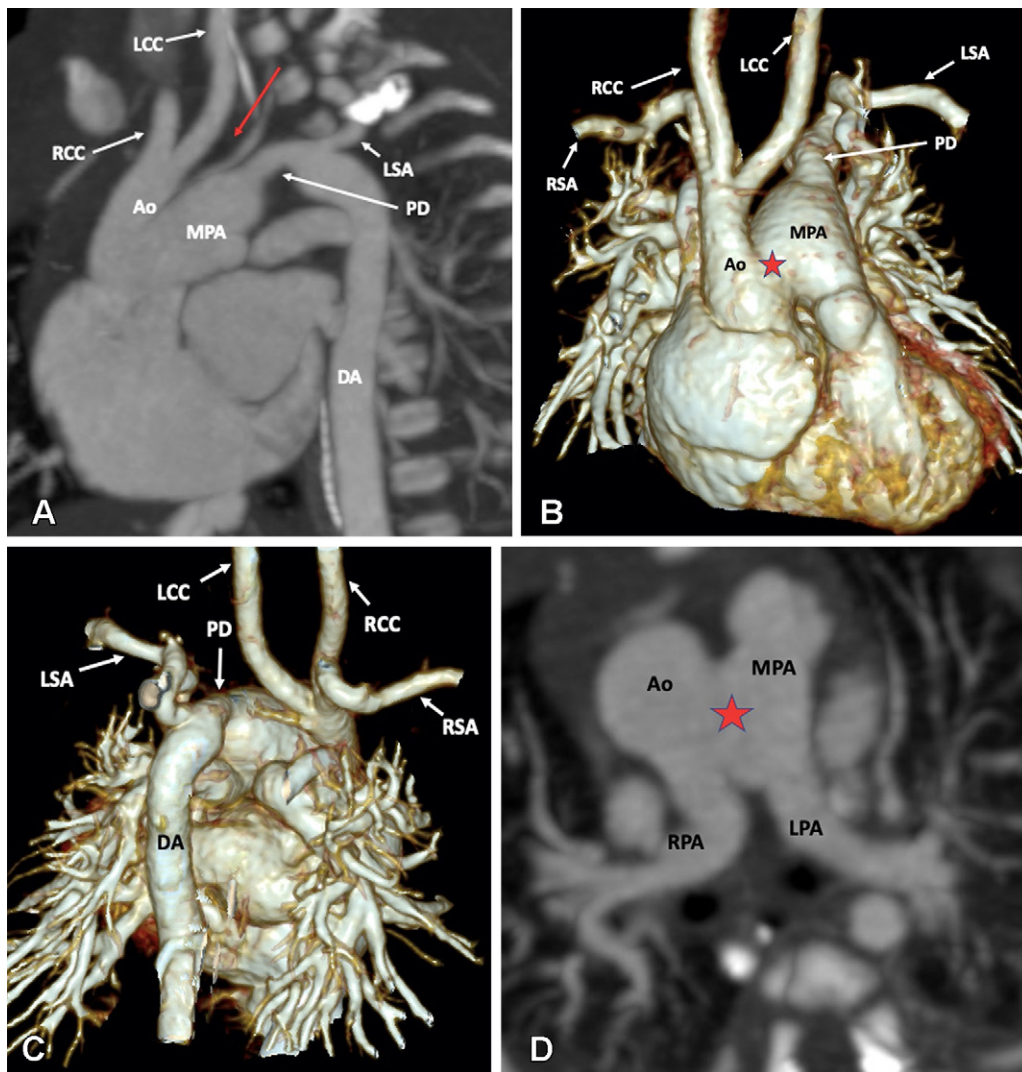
Preoperative appearance of type B interrupted aortic arch with aortopulmonary window in a neonate. (A) Sagittal oblique maximum intensity projection (MIP) CT image shows interrupted aortic arch (red arrow). Both the right and left common carotid arteries arise from the arch proximal to the site of interruption. The descending thoracic aorta is filled by a large left patent duct connecting the left pulmonary artery and descending thoracic aorta. (B) Anterior and (C) posterior three-dimensional volume-rendered images confirm the aortic arch interruption. The proximal ascending aorta and pulmonary trunk are connected, suggesting aortopulmonary window (red star in B). (D) Axial MIP CT image shows aortopulmonary window (red star). Ao = aorta, DA = descending aorta, LCC = left common carotid artery, LPA = left pulmonary artery, LSA = left subclavian artery, MPA = main pulmonary artery, PD = patent duct, RCC = right common carotid artery, RPA = right pulmonary artery, RSA = right subclavian artery.
